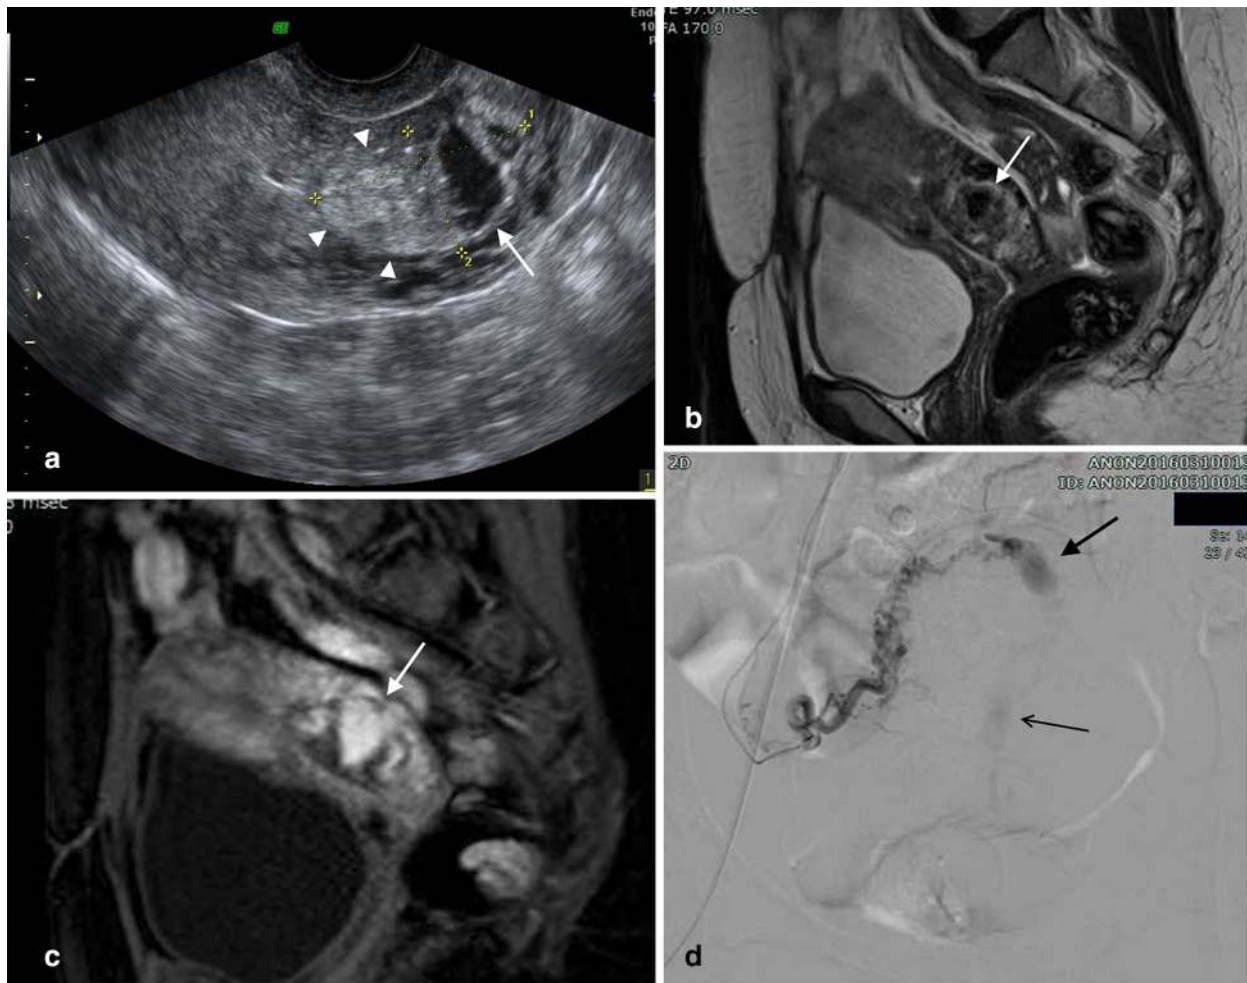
44-year-old woman with massive genital bleeding 2 months after a cesarean delivery for placenta accreta. a Grayscale ultrasound reveals an echogenic mass (arrowheads) with an anechoic component (arrow), mainly in the lower segment of the posterior uterine wall, protruding into the endometrial cavity. Doppler ultrasound showed prominent vascular flow within the anechoic component of the mass; the peak systolic velocity was greater than 80 cm/s (not shown). b MRI shows a large flow void (arrow) within the mass on
